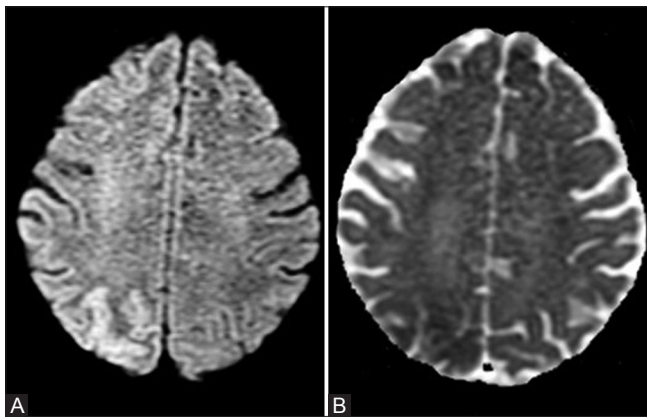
(A and B): Axial DWI (A) image shows cortical hyper-intensity with corresponding low signal on ADC (B) i.e., restricted diffusion involving the right parietooccipital region
